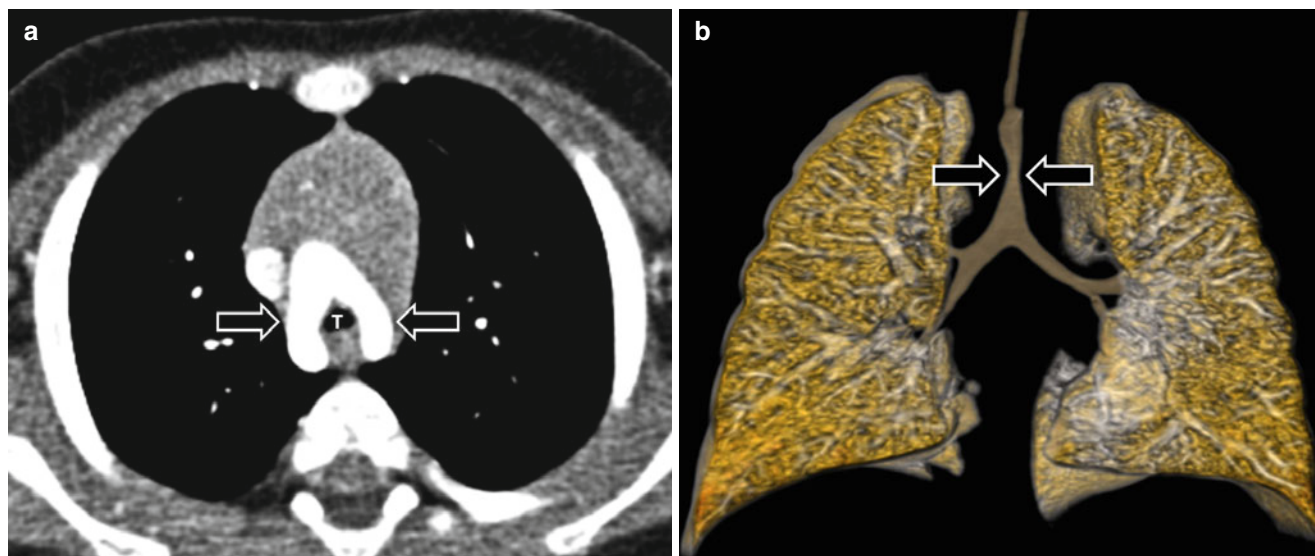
Double aortic arch in an 8-month-old boy who presented with stridor, difficulty of feeding, and repeated apnea. (a) Enhanced axial CT image shows two (i.e., right and left) aortic arches (*arrows*)
